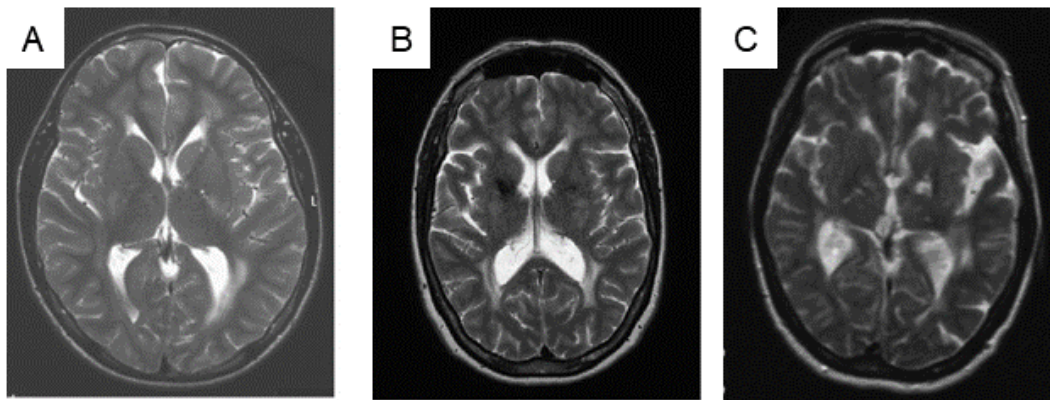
MRI images of COL4A1^{G755R} family cases: T2 MRI axial view of (A) index case (B) the index case's mother and (C) the index case's grandmother; modified from²⁶⁸
